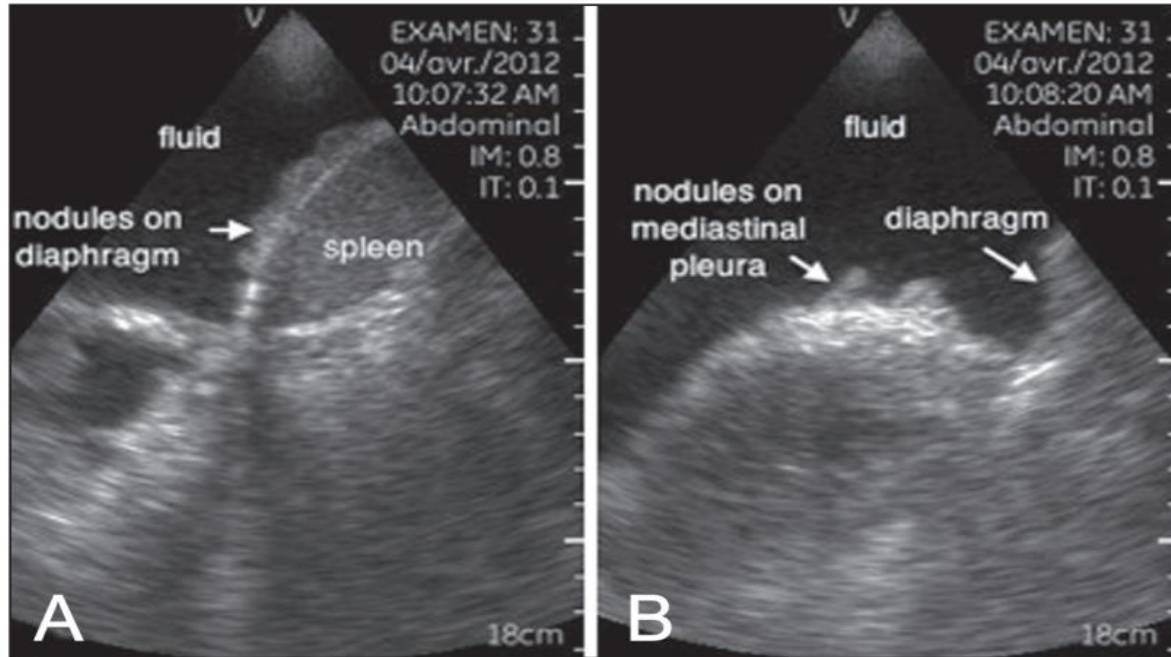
Ultrasound images (Vscan, GE Healthcare, USA) (1.7 MHz to 3.8 MHz probe) of nodules on the diaphragm (A) and nodules on the mediastinal pleura (B)
